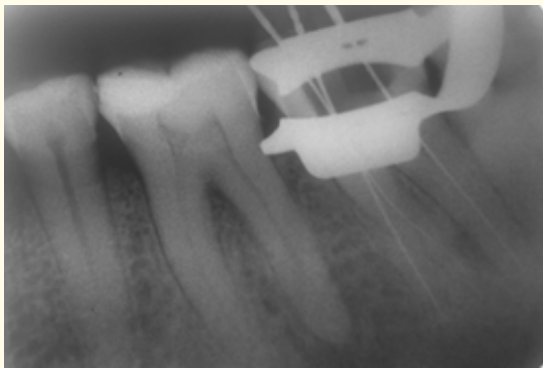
The working length measurement radiograph confirmed the presence of three files in three separated roots.
